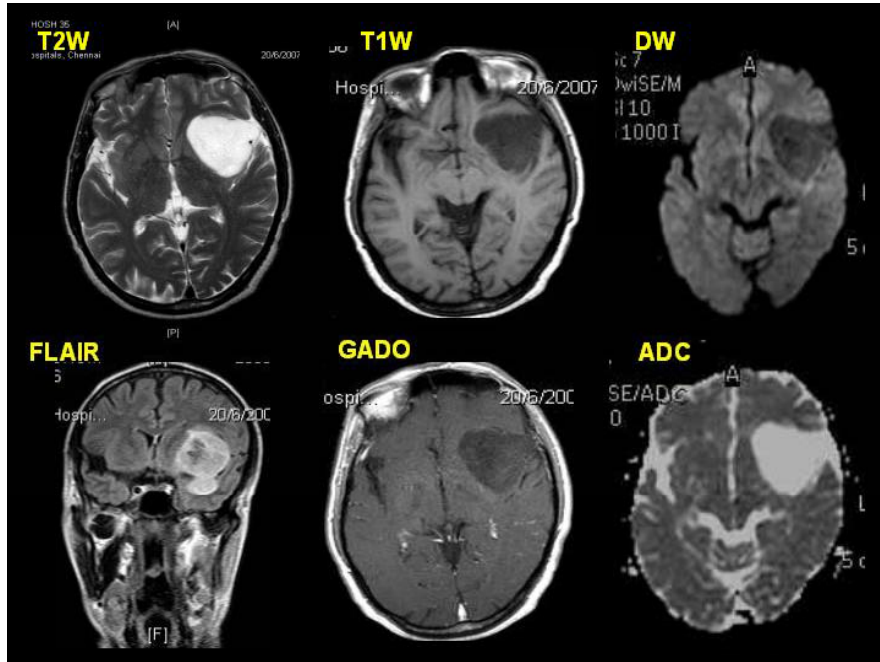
MRI shows a well-defined, non-enhancing lesion in the left fronto-temporal lobe; it displays hypointense on T1 WI, hyperintense on T2 WI and non –restricted on DWI. Non specific.
